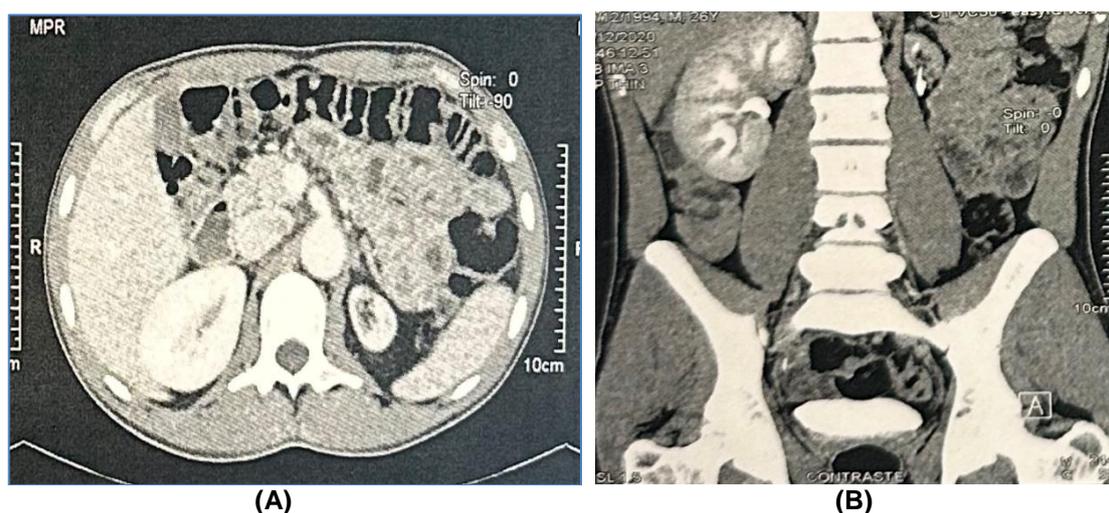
A/B CT scan shows a nephritic kidney
